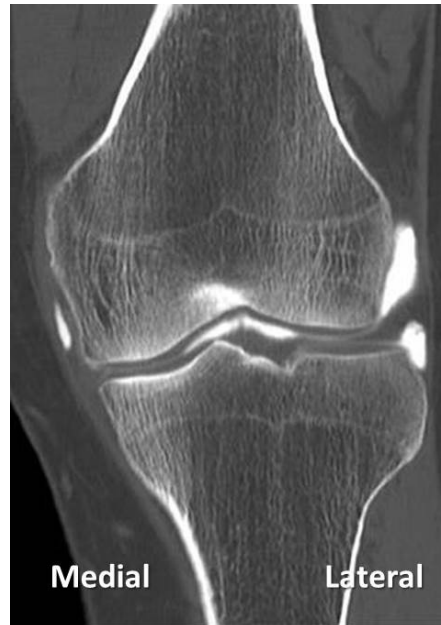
Bony anatomy of the proximal tibia. Coronal plane CT arthrogram image showing varus proximal tibia with dense subchondral platforms, epiphyseal scar and cortical bone thickening at the metaphyseal flare.
